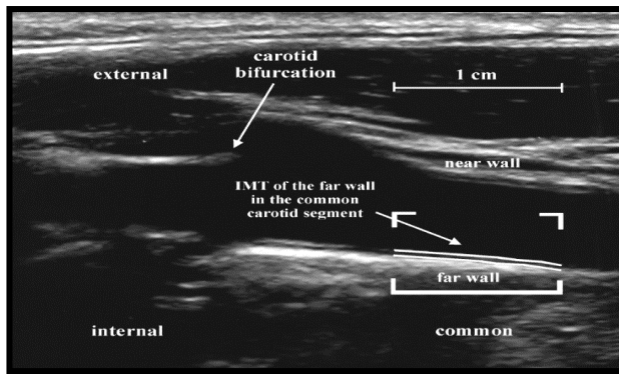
Longitudinal ultrasound image of the distal common carotid artery [9].
